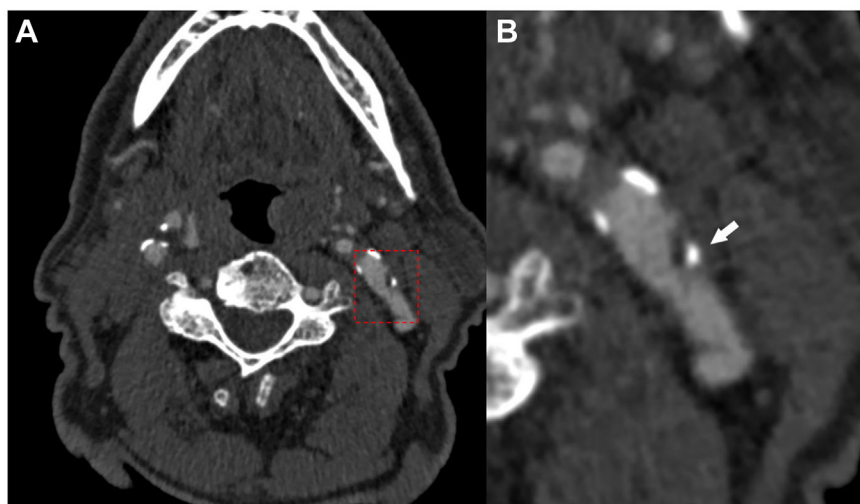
Intraluminal thrombus observed in the left carotid artery of an 82-year-old man with an ipsilateral ischemic stroke. Computed tomography (CT) scan shows an intraluminal filling defect in the left carotid artery indicative of a clot (A and B).
